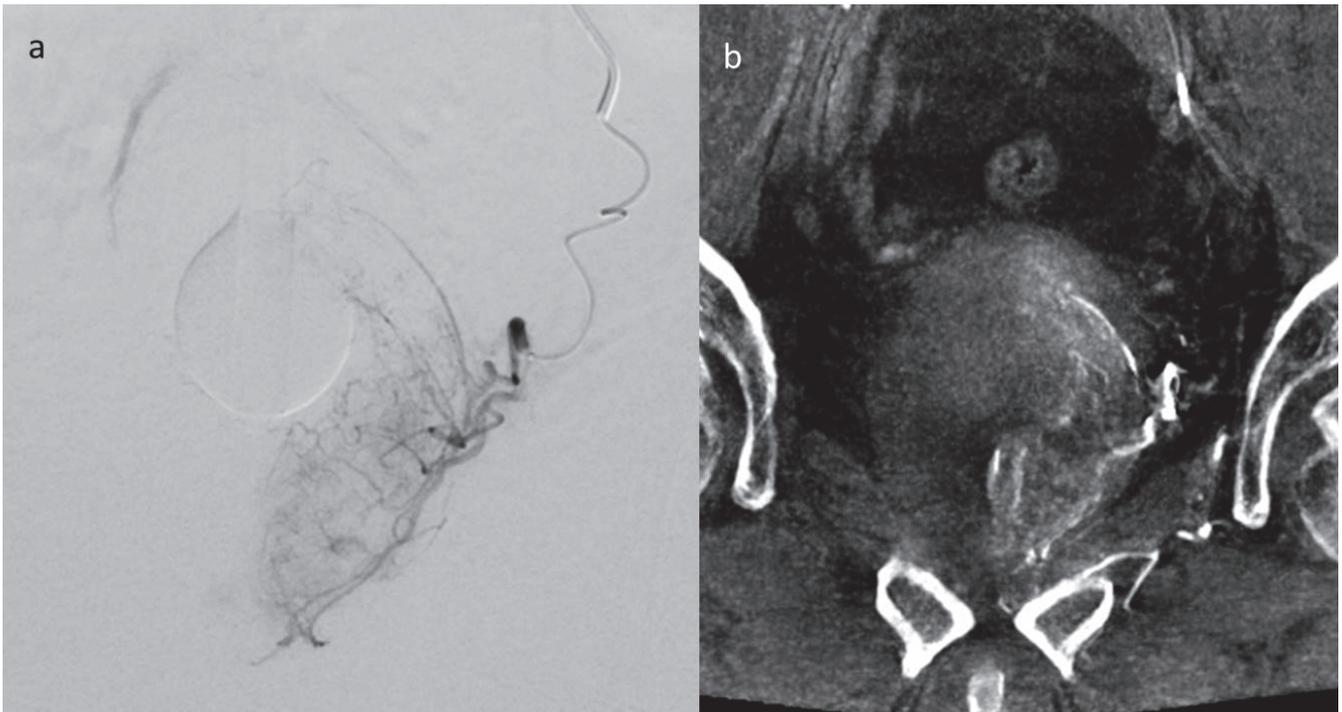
(a) Superselective Digital Subtraction Angiography (DSA) and (b) Cone Beam Computed Tomographic Angiography (CBCTA) of the left prostate artery.
